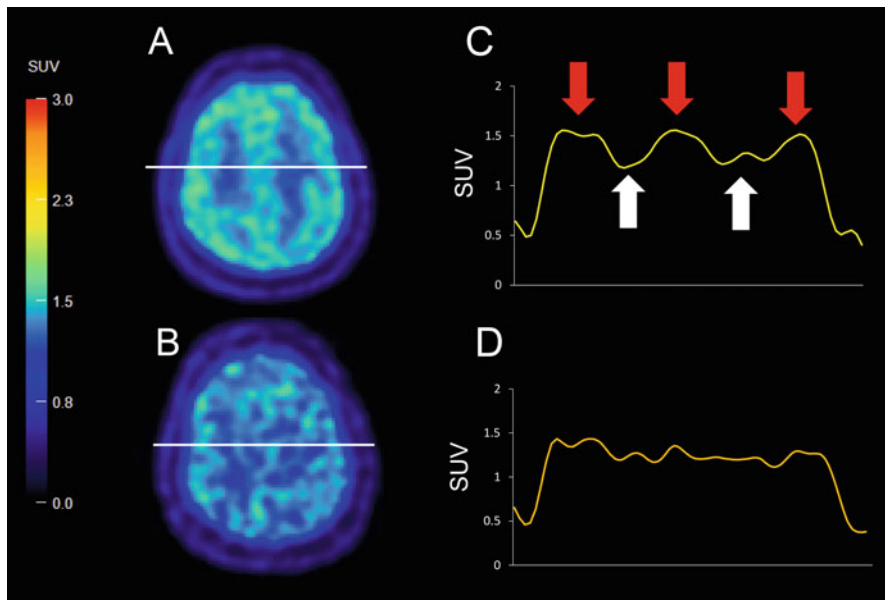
A brain slice FMISO PET image (a) 2 h after administration of FMISO and (b) after 4 h. No tumor existed on these slices. (c) 2-h SUV profile corresponding to the horizontal line in (a). The red arrows indicate gray matter, and the white arrows indicate white matter. (d) 4-h profile corresponding to the horizontal line (b)
